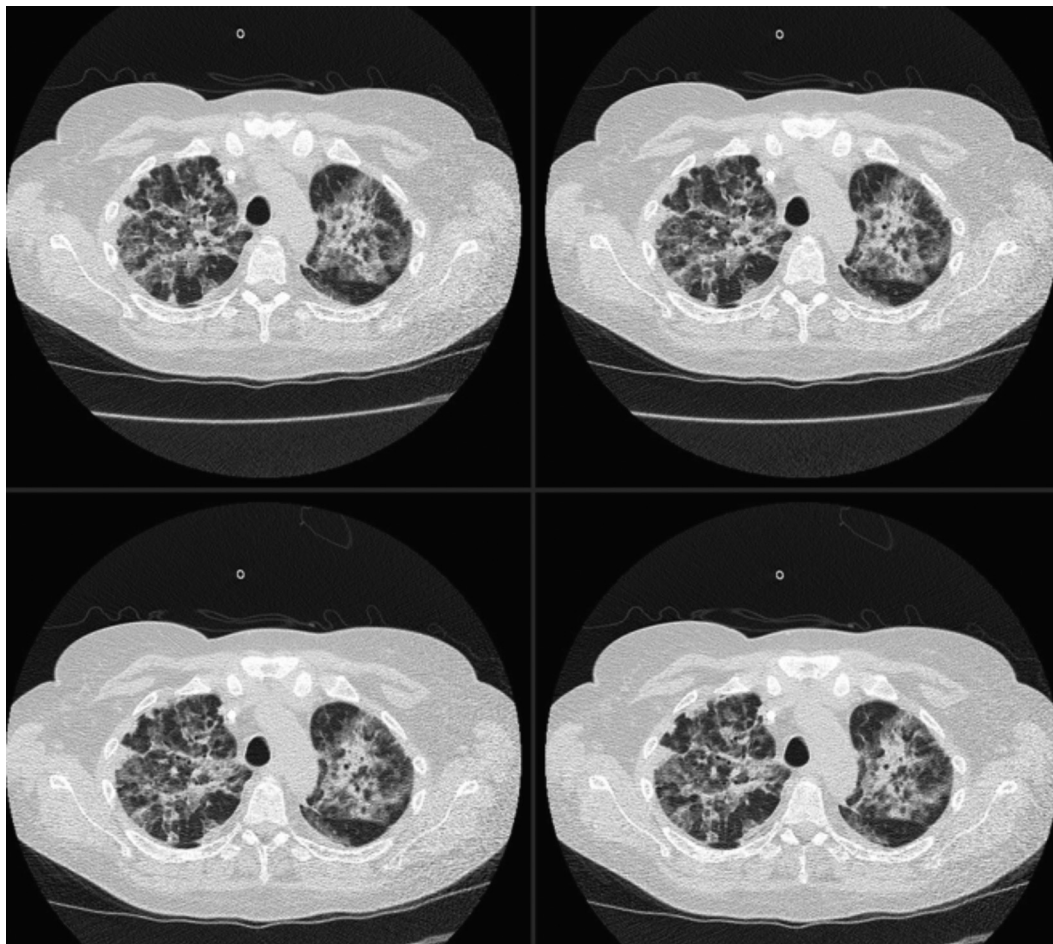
Case 18. Chest computed tomography scan. Changes in the course of COVID-10. The high-resolution computed tomography scan of the chest revealed extensive consolidation and frosted glass changes, covering 75% to 80% of lung volume.
